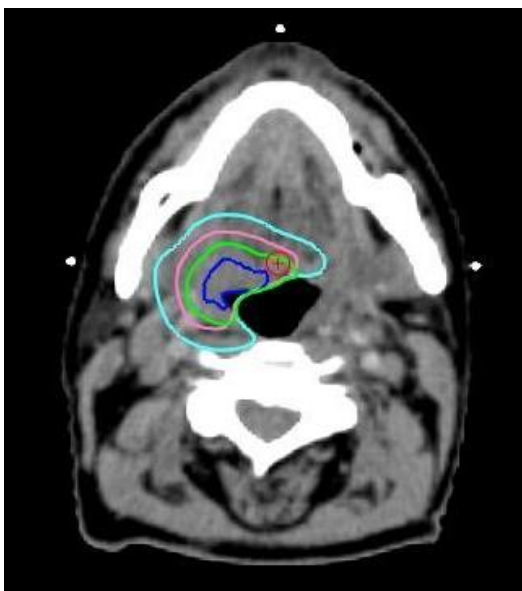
Cross sectional imaging of the phase 2 planning CT. bGTV\_iP contoured in blue, bCTV1\_P in green, CTV1\_P in pink and CTV2\_P in light blue
